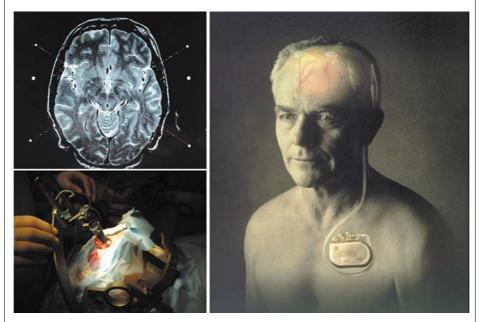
T2 weighted stereotactic axial brain MRI image showing STN nuclei marked for calculation of sterotactic coordinates. Panel below shows electrode implantation using rigid stereotatic frame. Right panel shows complete DBS system including implanted pulse generator, connecting cables and brain electrodes, which is all internalised under the skin.
